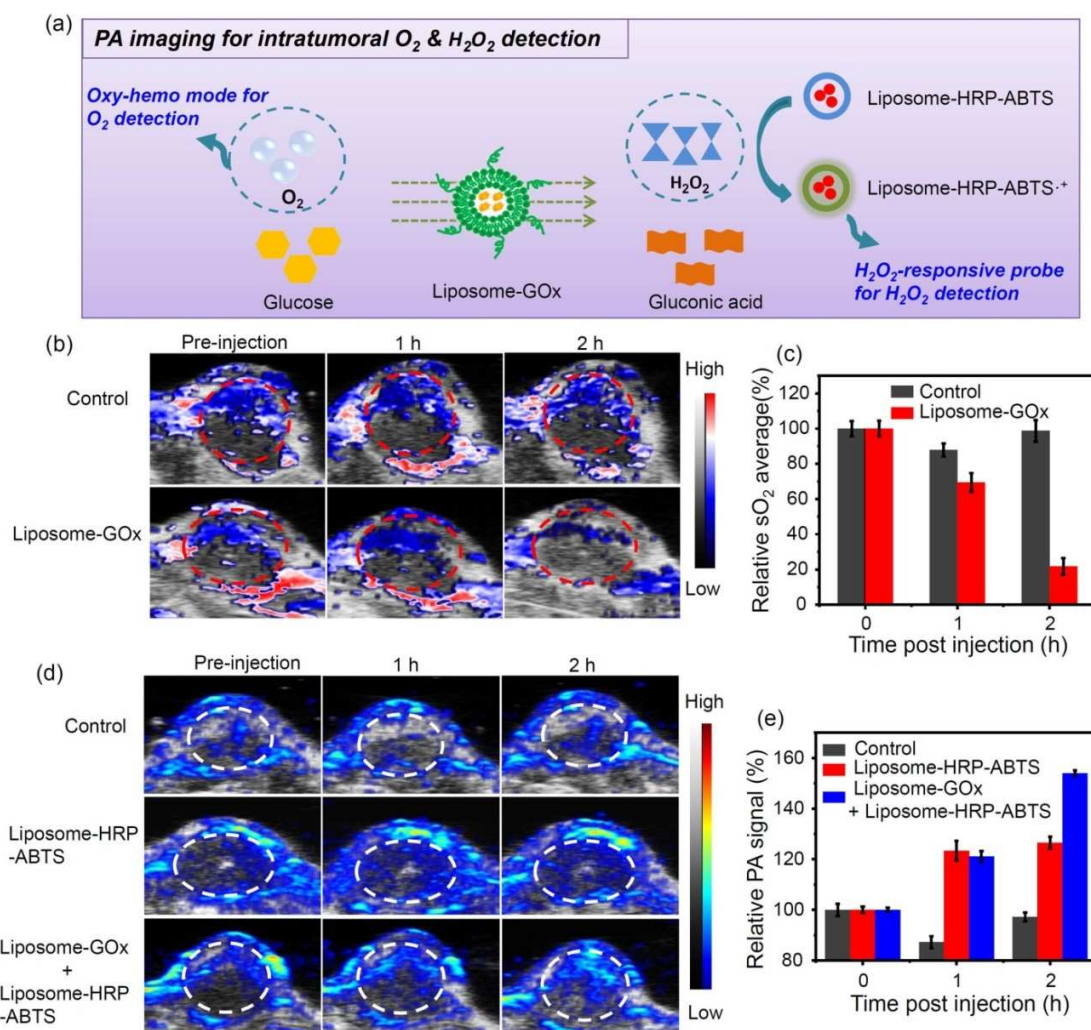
Tumor hypoxia and H_2O_2 detection after injection of liposome-GOx by in vivo PA imaging. (a) A scheme of PA imaging of intratumoral O_2 and H_2O_2 . (b) PA images of 4T1 tumor blood oxygen saturation (sO_2) levels before or at different time intervals after i.v. injection of liposome-GOx or saline. The color scale was calculated from the PA signal ratios between de-oxygenated (750 nm) and oxygenated hemoglobin (850 nm). The grey scale was B-mode ultrasound signals. (c) Quantification of sO_2 average total signals in (b). (d) PA images of 4T1 tumors to detect intratumoral H_2O_2 by the liposome-HRP-ABTS nanoprobe, without or with co-injection of liposome-GOx. (e) Quantification of H_2O_2 -induced PA signals for tumors in (d).
